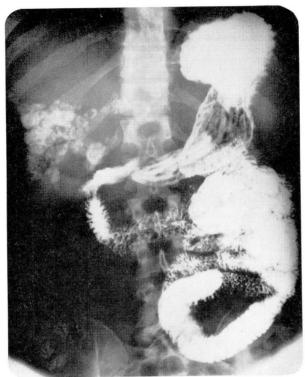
Upper gastrointestinal roentgenogram showing rounded, irregular, dense, intrahepatic calcification.
